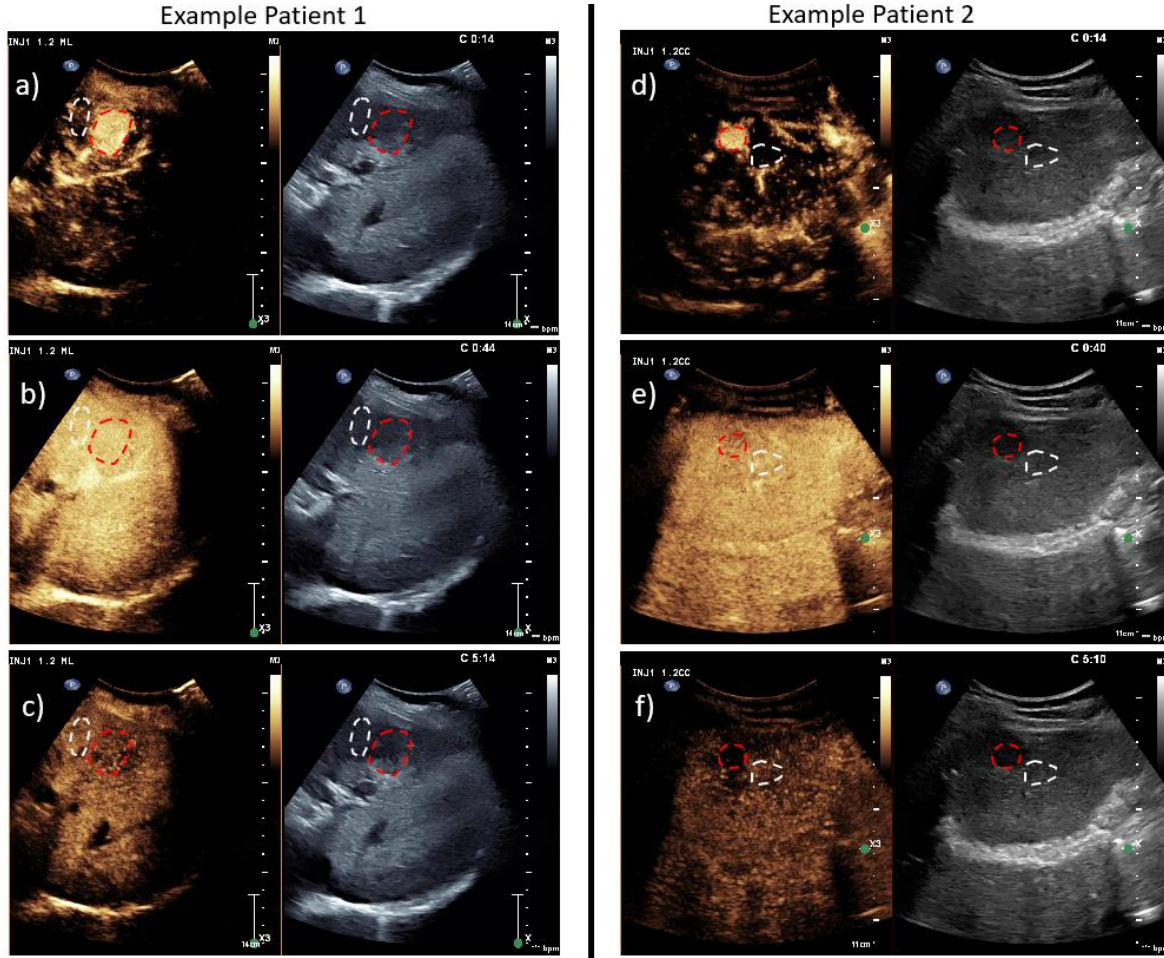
Contrast-enhanced ultrasound (CEUS) and conventional B-mode images for two example hepatocellular carcinoma (HCC) patients at three timepoints throughout the scan: the peak of the arterial phase (a,d), the peak of the portal phase (b,e), and the late phase (c,f). The red regions of interests (ROIs) are placed around the lesion, while the white ROIs are placed at a similar depth as the lesion and sample the surrounding parenchyma.
